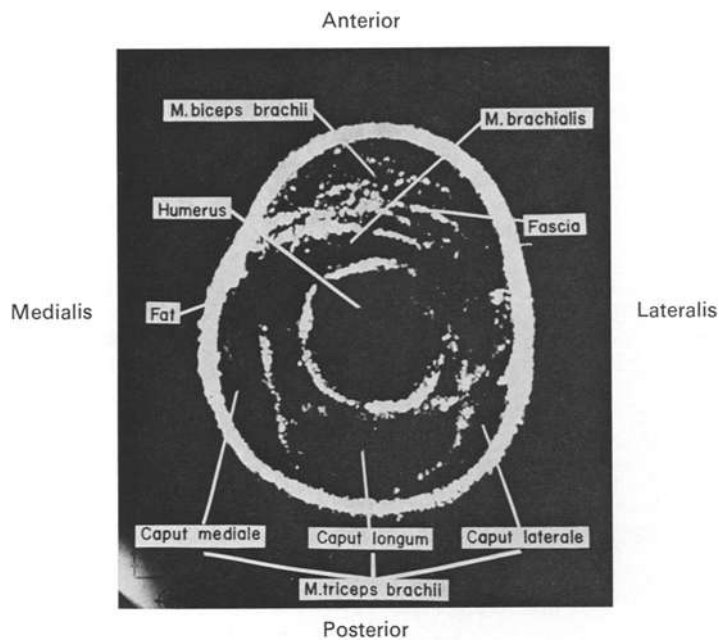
Cross-sectional view of human upper arm by ultrasonic method
